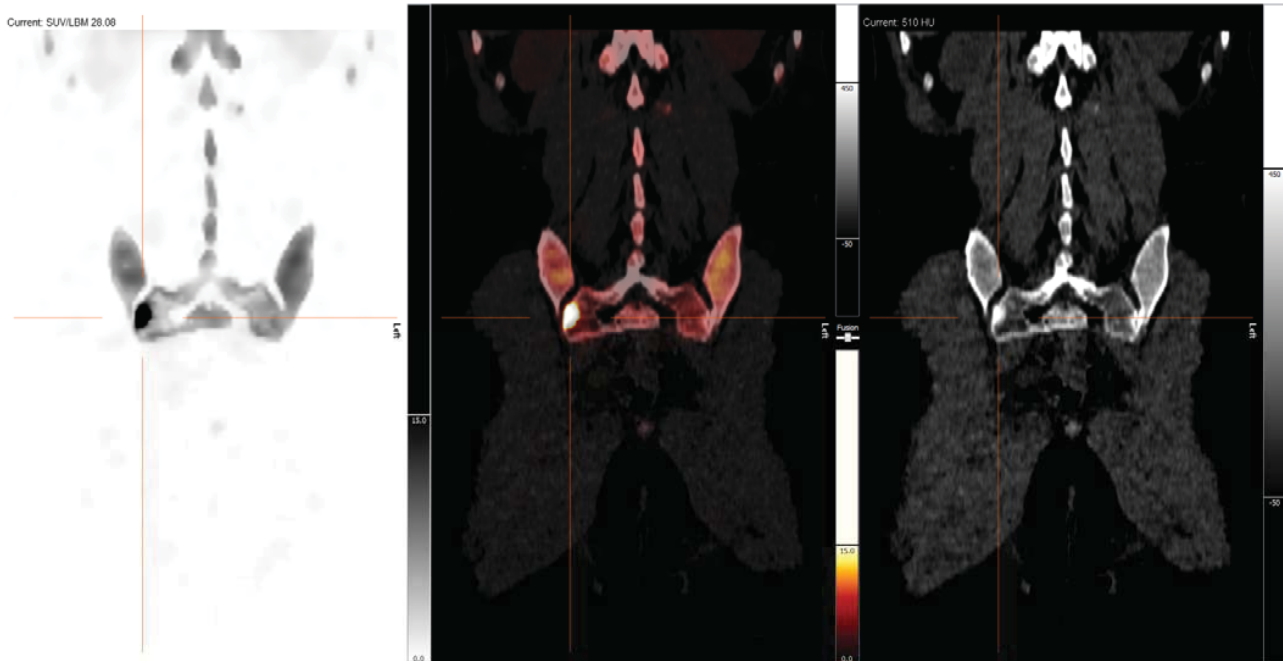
Case 1: SPECT image, SPECT/CT image and CT images (metastasis, SUV/LBM max 28.08)
